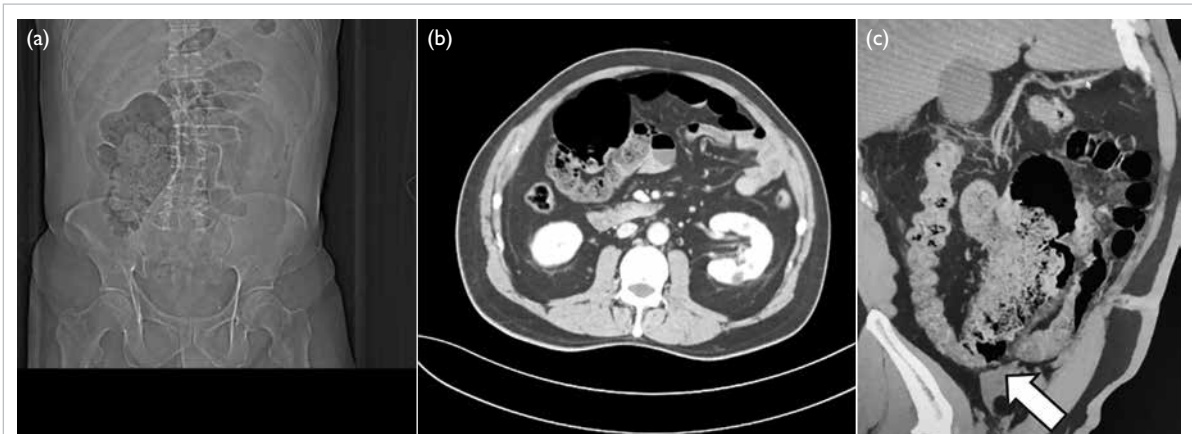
Cross-sectional imaging of the abdomen. (a) Scout film. (b) Axial computed tomography. (c) Oblique sagittal computed tomography, with the folding point shown (arrow)
